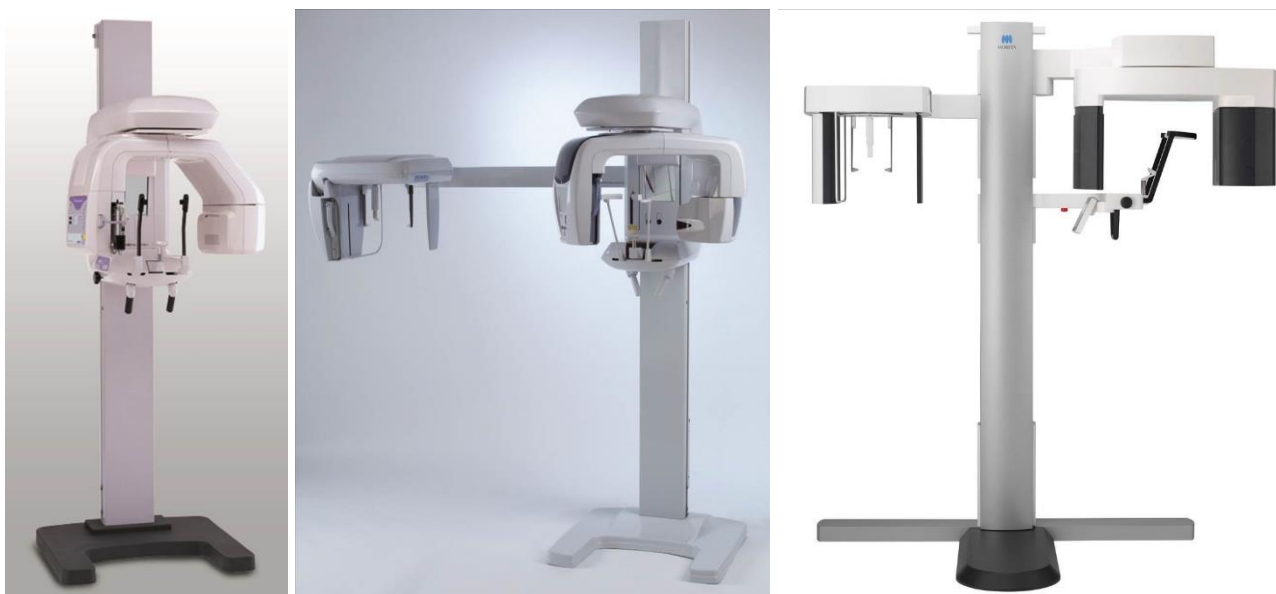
Left: Digital panoramic system 'Veraviewepocs' (1998, J Morita, Kyoto, Japan). Middle: Veraviewepocs 3D, a '3-in-1' (panoramic/cephalometric/cone-beam CT) system (2007, J Morita). Right: Veraview X800 (2016, J Morita) 3-in-1 unit. Courtesy of J Morita.
